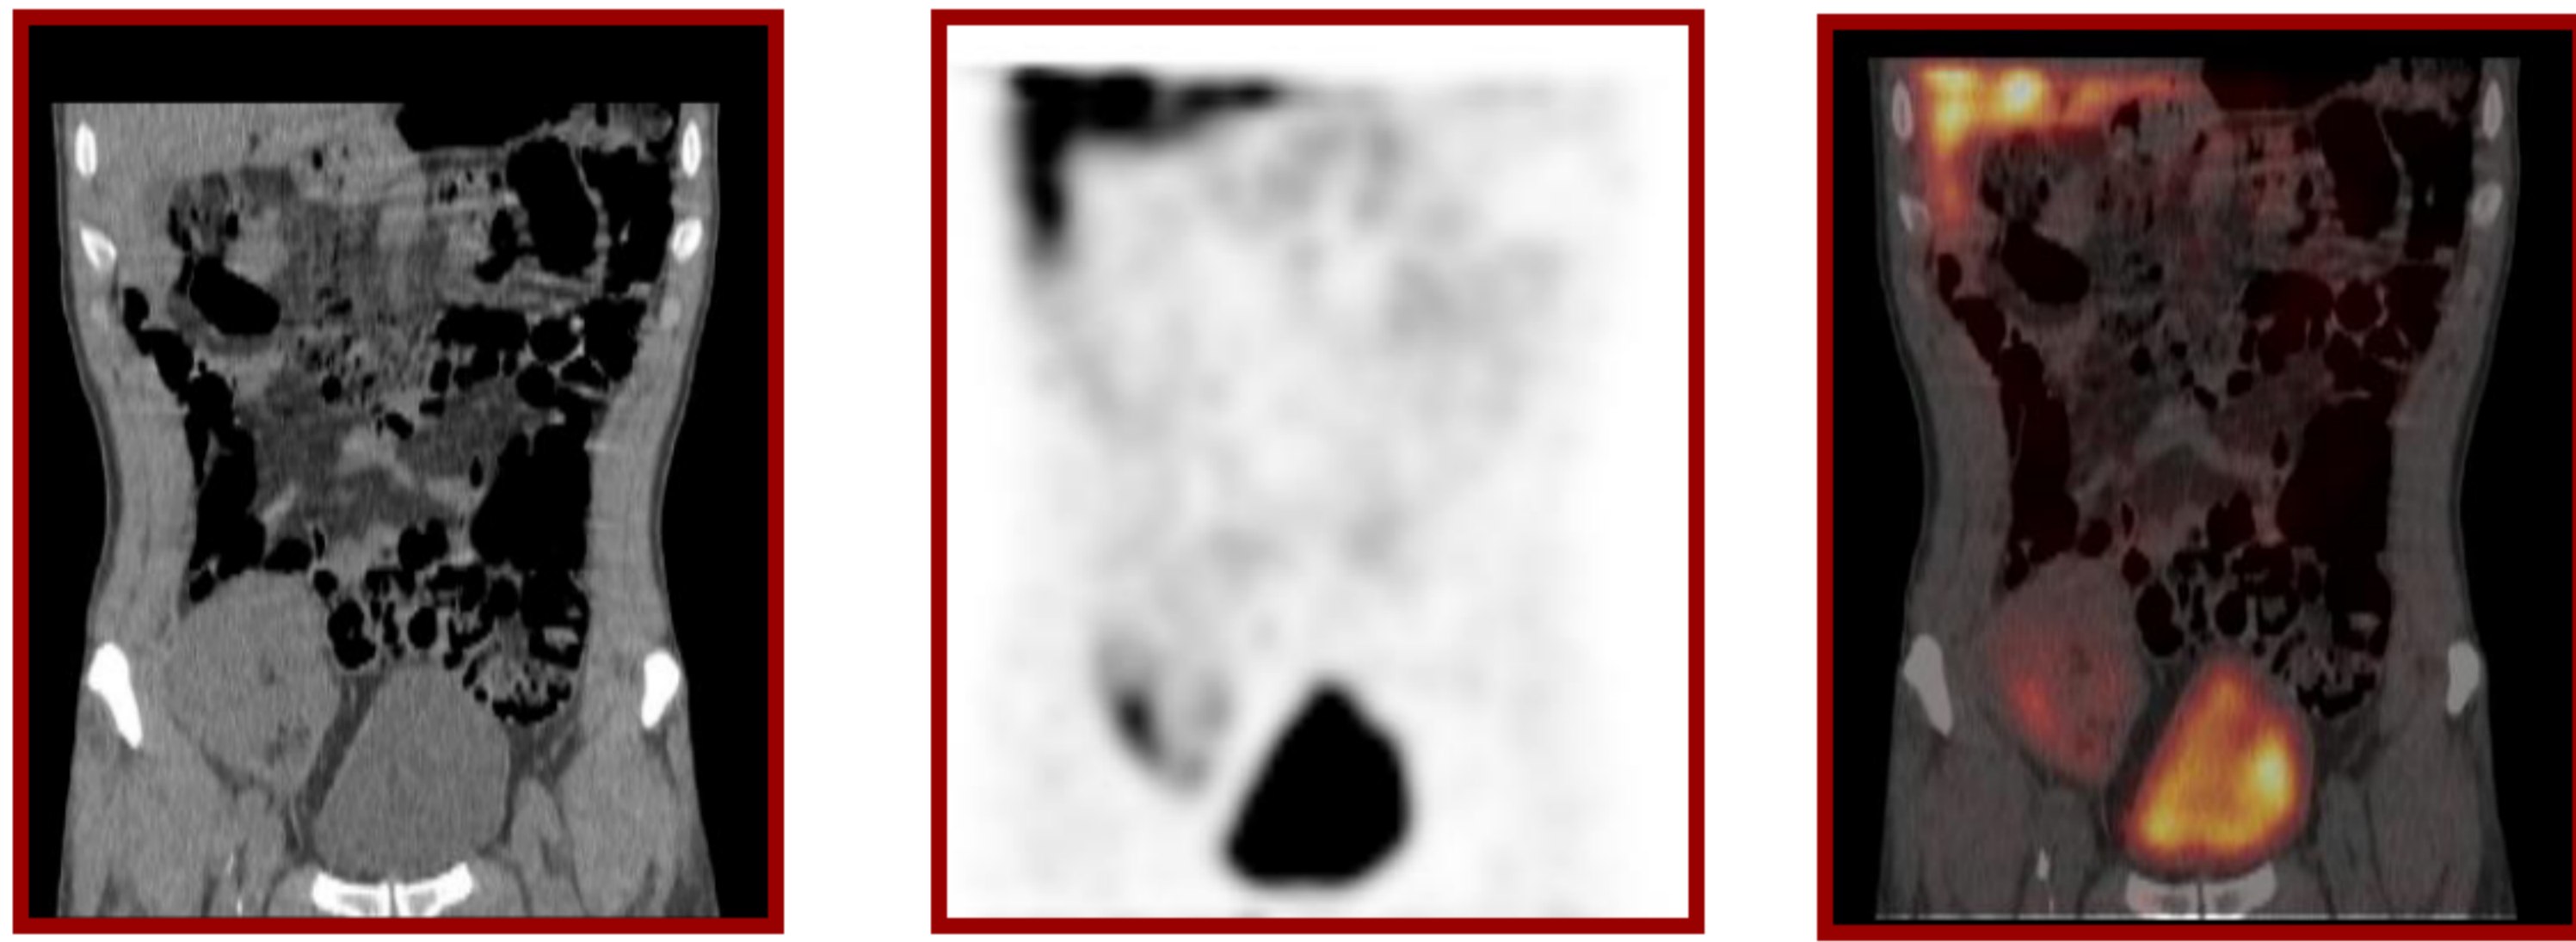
Left panel CT scan, middle panel SPECT and right panel the fused SPECT-CT
